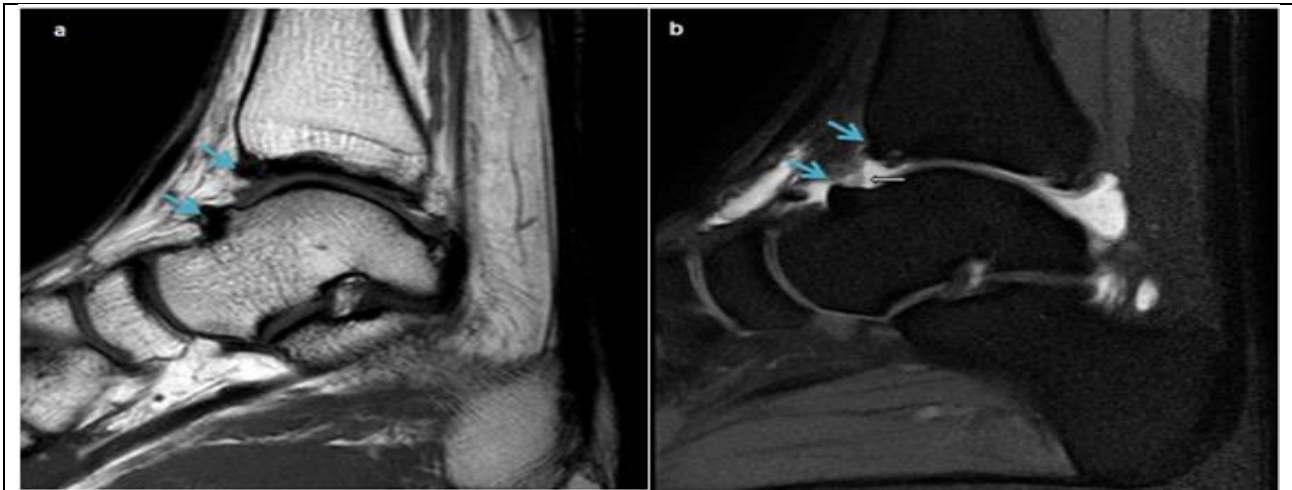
Male patient, 33 years old presented with chronic right ankle pain and limitation in dorsiflexion. (a) Sagittal T1 weighted spin echo conventional MRI shows anterior bony impingement in terms of tibial and talar neck spurs (kissing lesions) (*Blue arrows*), (b) sagittal T1 SPIR MR arthrogram shows anterior bony and soft tissue impingement in terms of tibial and talar neck spurs (kissing lesions) (*Blue arrows*) and synovitis in anterior capsular recess (*white arrow*). Arthroscopy revealed: Anterior bony and soft tissue impingement (Anterior tibial and talar spurs with anterior capsular recess synovitis).
